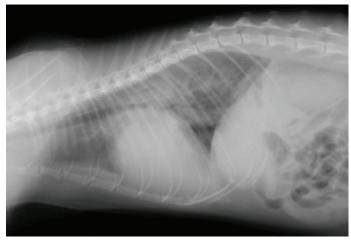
Left lateral thoracic radiograph (conscious).
